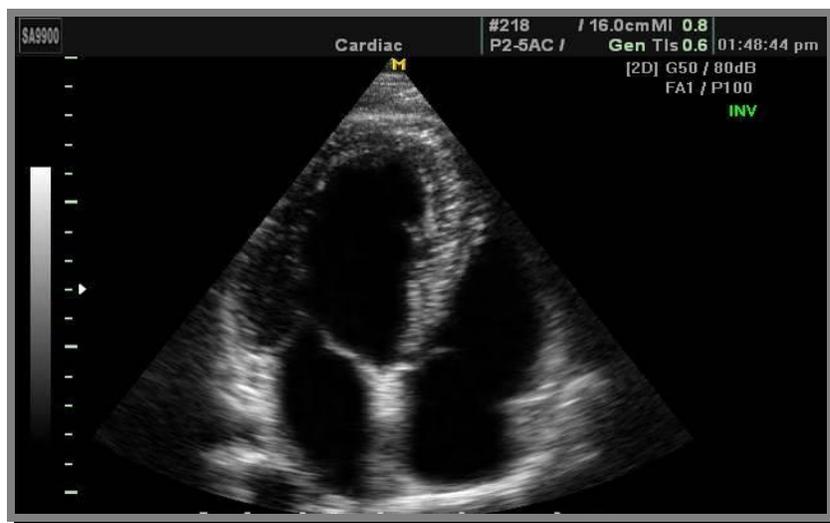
Apical 4 chamber view.*
